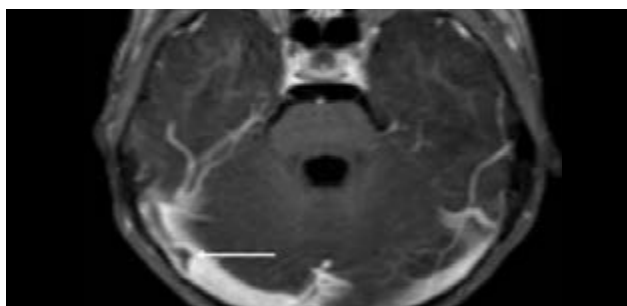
MRI of a 41-year-old woman presenting with headache. Axial T1WI sequence showing signs of dural venous thrombosis in the right transverse sinus (arrow).
